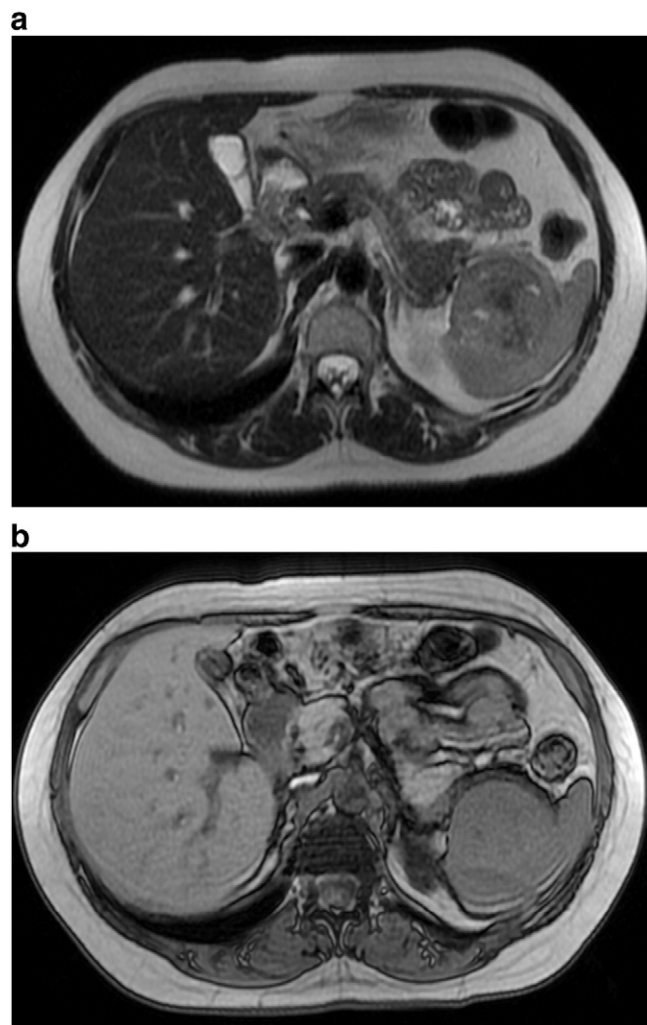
(a) Axial T2-weighted single-shot fast spin echo abdominal MRI shows a predominantly isointense splenic mass with a hypointense center and multifocal areas of hyperintensity. (b) Axial out-of-phase Gradient Echo image shows no areas of signal reduction to indicate intracellular lipid within the splenic mass.
